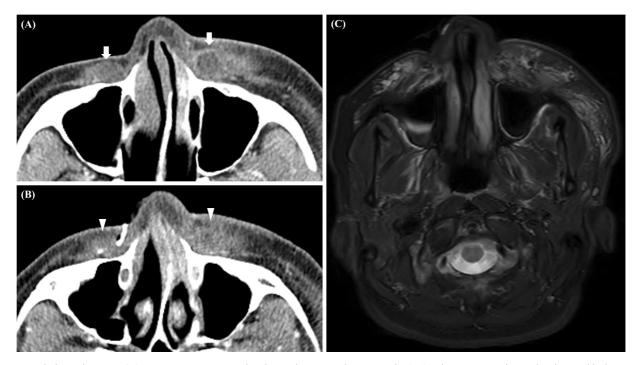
Radiological images. (A) Preoperative image with enhanced computed tomography (CT). White arrows indicate the abscess-like lesion on both cheeks. (B) Postoperative 1-day image with enhanced CT. White triangles indicate the sequelae after removing the abscess. (C) Postoperative 1-day image with magnetic resonance imaging. Diffuse soft tissue inflammation was observed on both cheeks.
